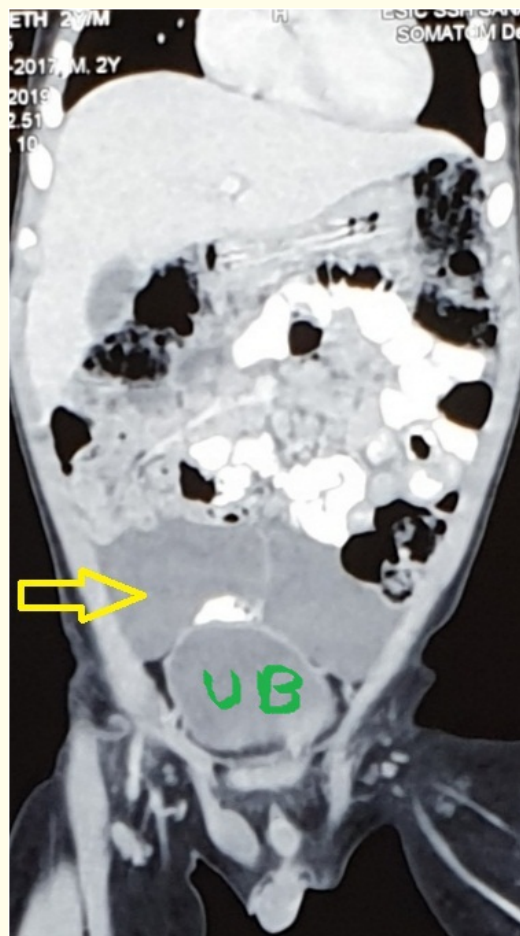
Contrast CT of abdomen showing a fluid-filled septate cystic lesion (yellow arrow) between the bowel loops and abutting the urinary bladder (UB) with no evidence of calcification or haemorrhagic foci.
